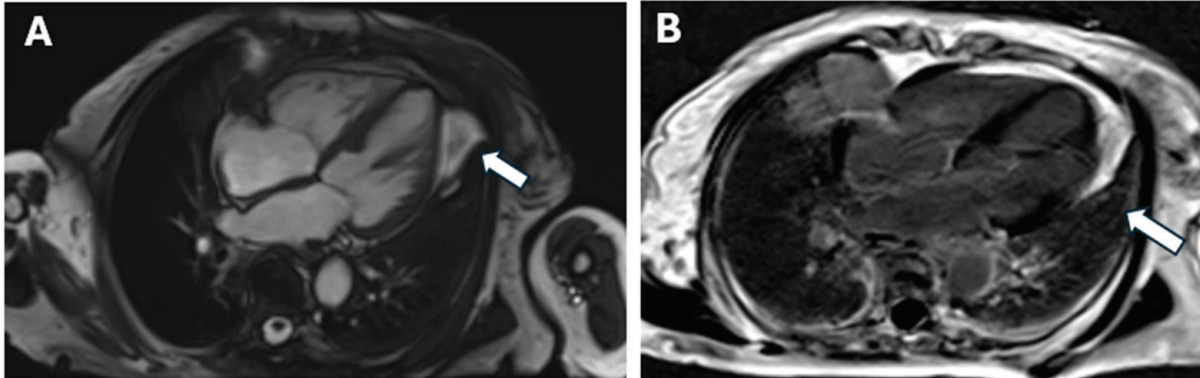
Cardiac MRI. (A) Aspect of chronic myocarditis; arrow—the lateral wall of the left ventricle with hypokinesia; no edema; (B) LGE PSIR; arrow—Gadolinium accumulation area in the lateral wall of the left ventricle.
